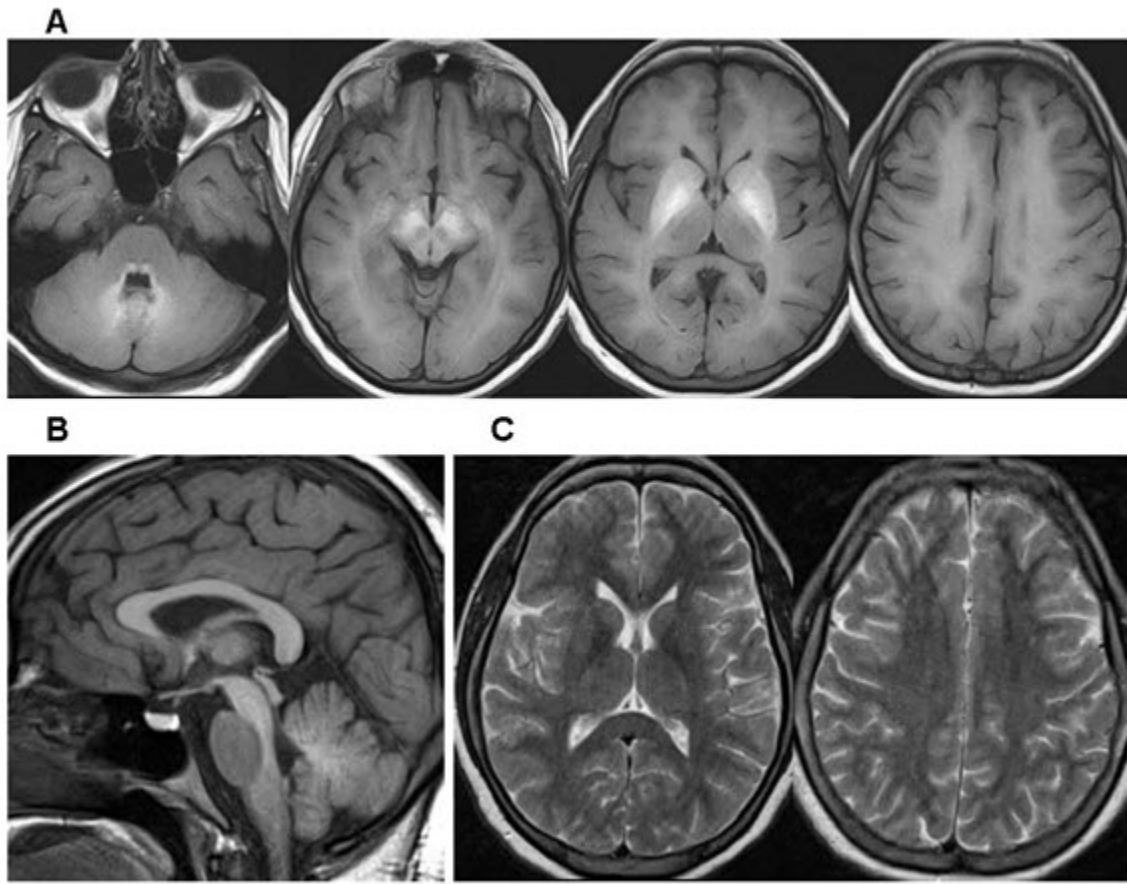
Representative brain MRI of an affected individual
